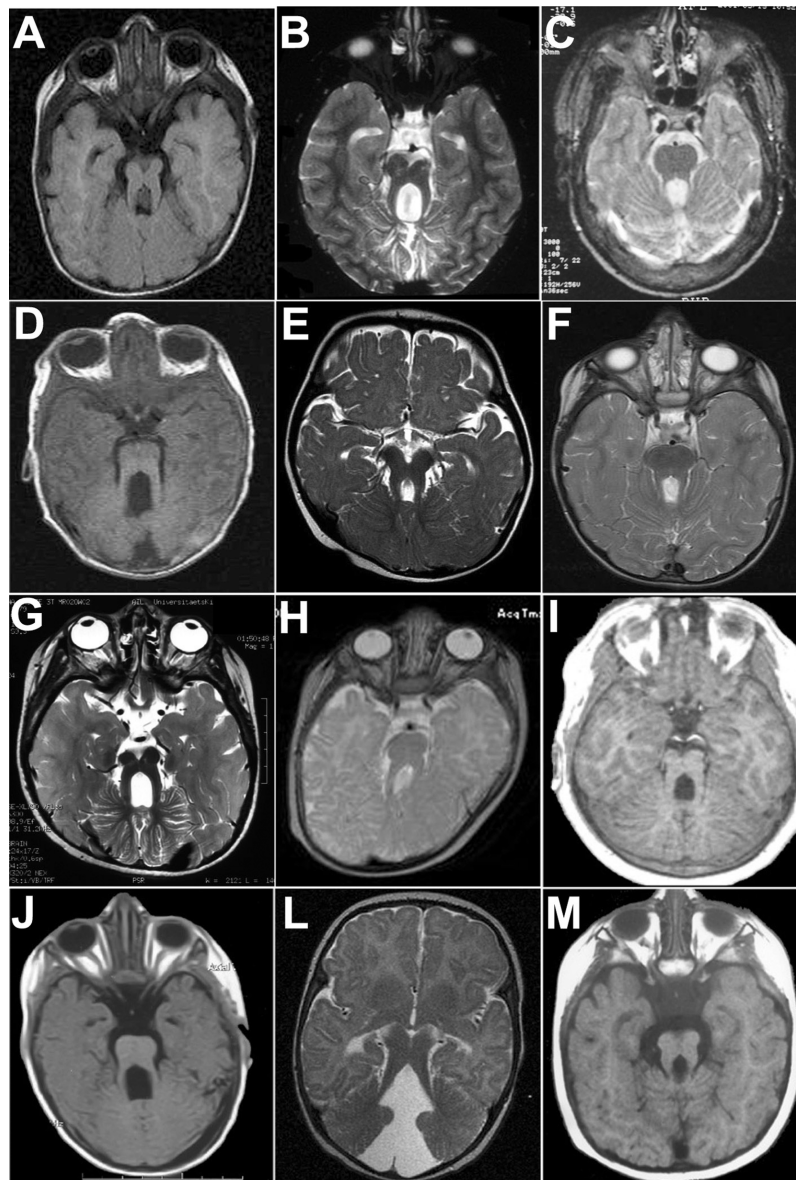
Brain magnetic resonance imaging results for 12 of 21 probands with mutations, showing the typical midbrain-hindbrain malformation known as the MTS. All panels display axial sections at the pontine or pontomesencephalic junction showing the MTS. A–L, respectively, patients MTI012, MTI286, COR002a, COR083, COR145, COR109, COR084, COR125, MTI333b, MTI154, MTI125, and MTI487.
